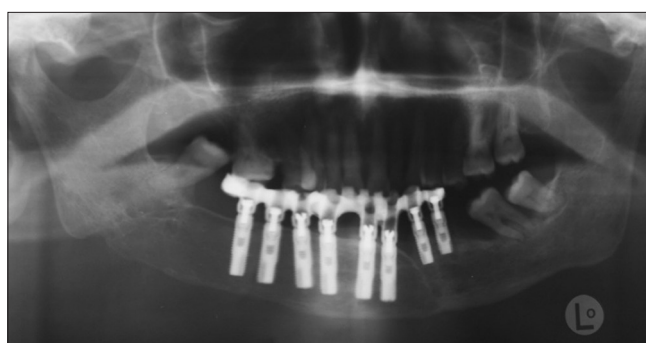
Five-years follow up of final prosthesis restoration. Radiographic control
